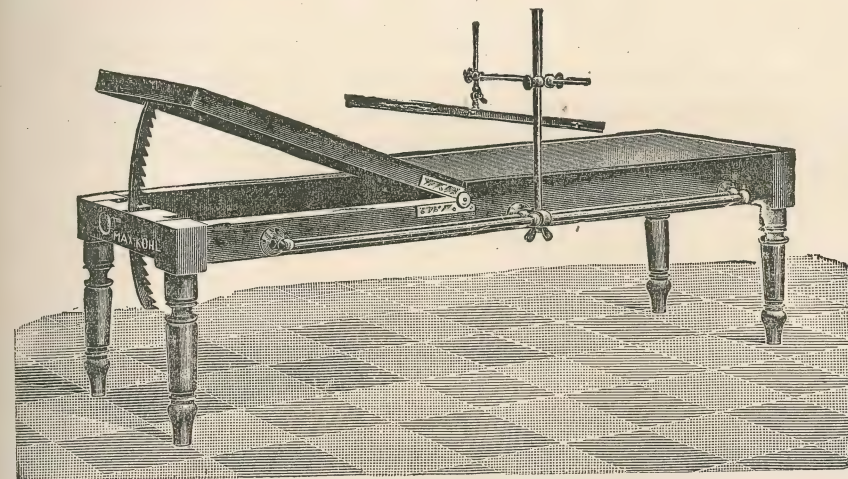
X-ray examination table with holder for light-tight case containing the plate and intensifying screens. This holder is so constructed that the case with plate for radiograph can be placed in position either under or over the table.
